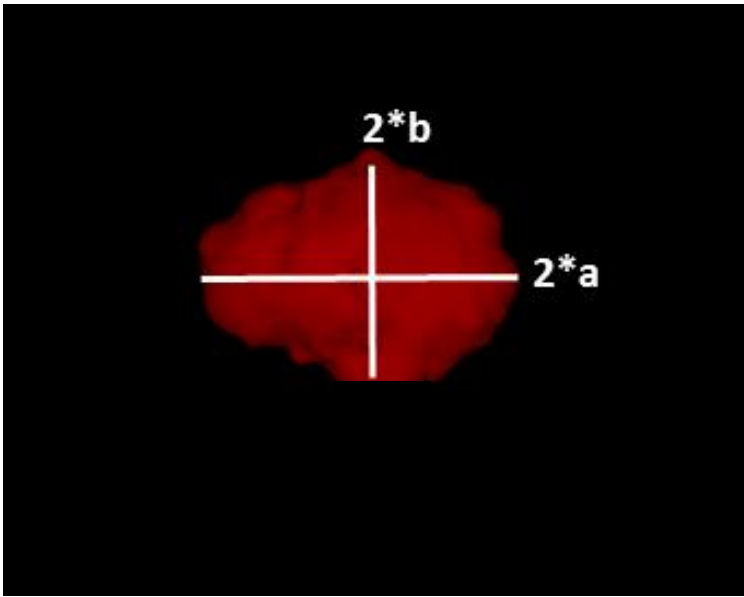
Reconstruction of hydrogel geometry based on MRI data of injections embedded in myocardial wall. Note that the shape is approximately ellipsoidal [24].
